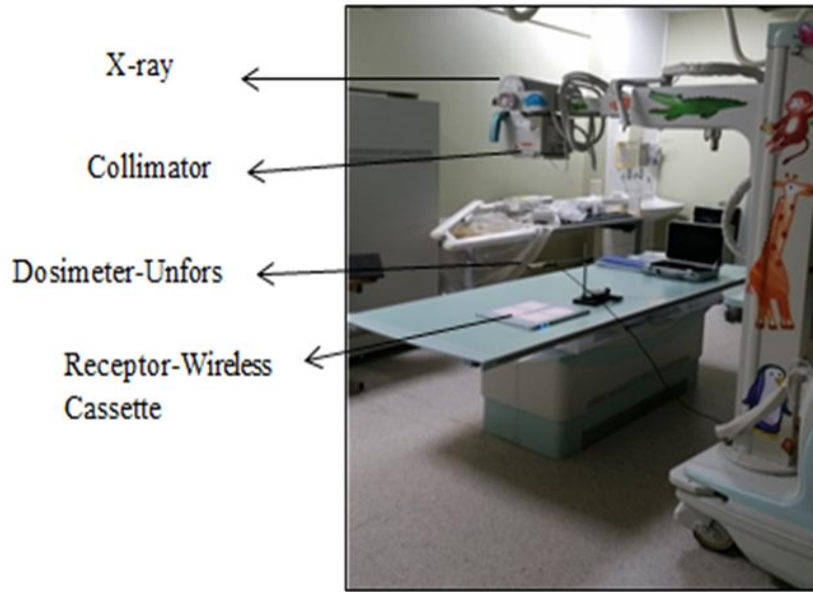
Air kerma measurements setup - Digital mobile x-ray
